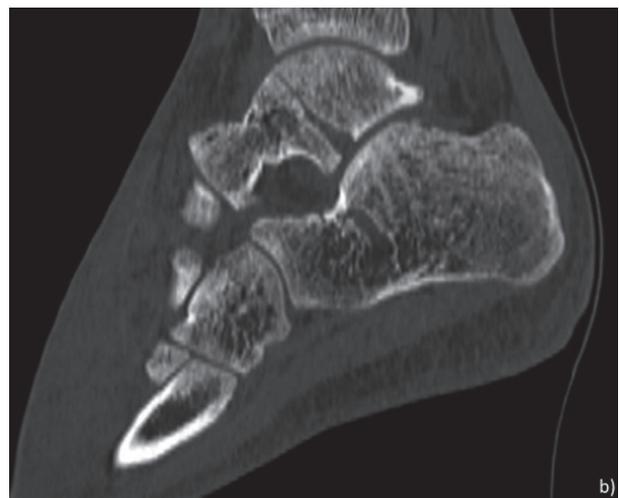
Two fragments body fracture. Axial CT scan (A) and sagittal Multi Planar Reconstruction
